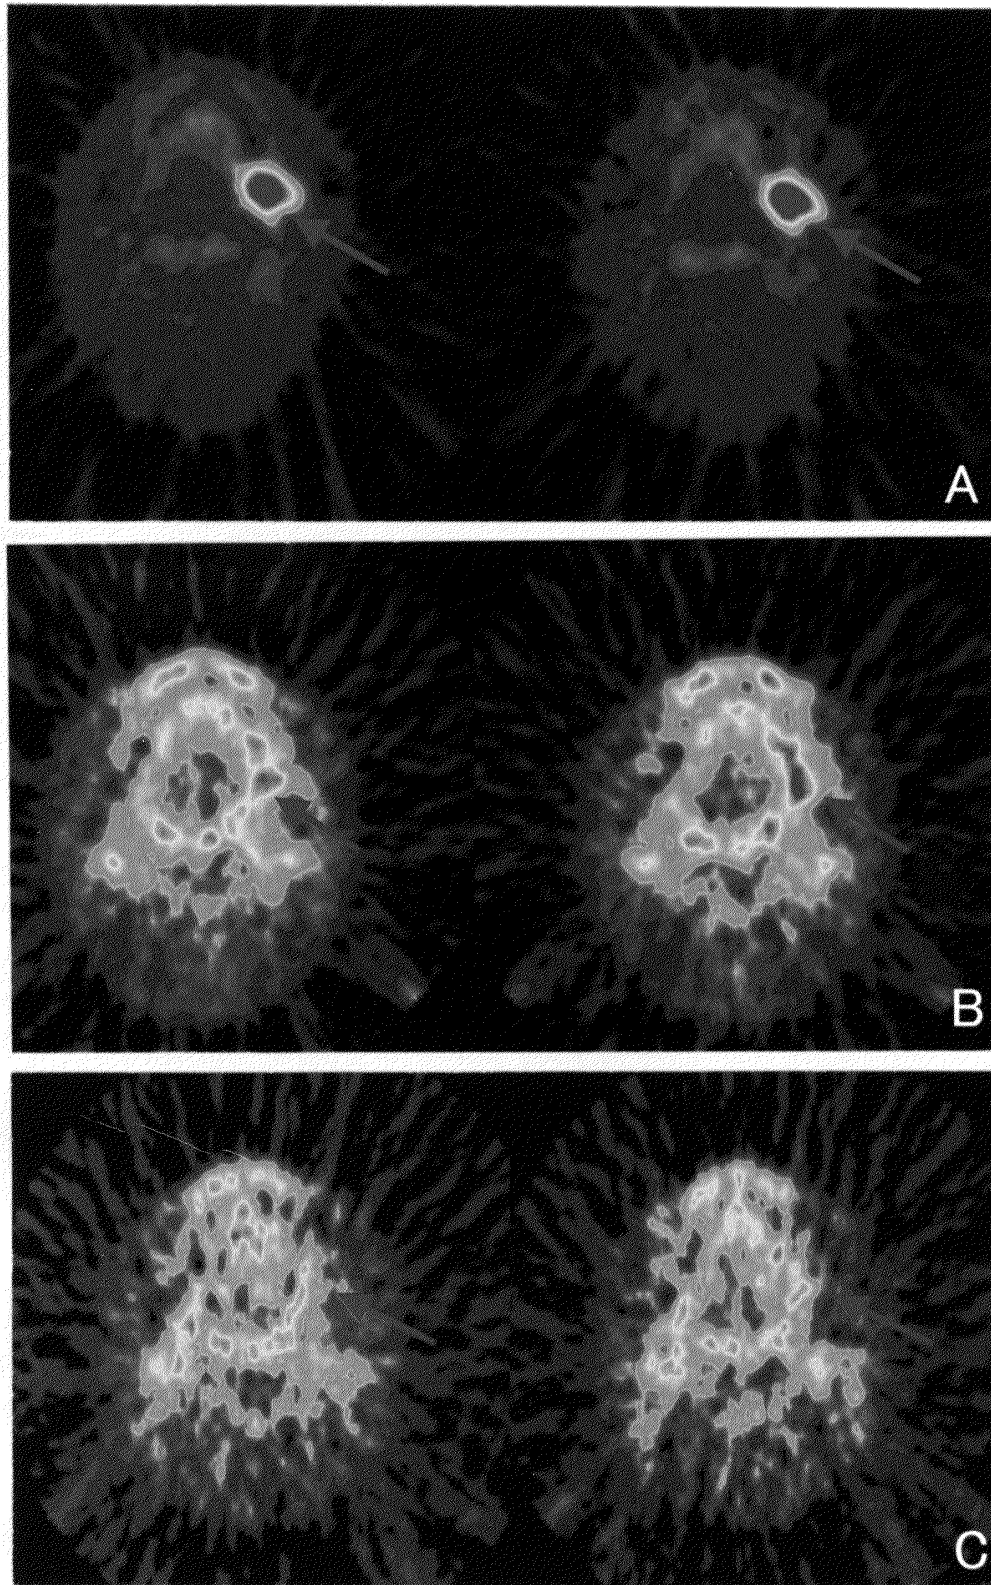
^{18}F -FDG-PET axial cut image.
